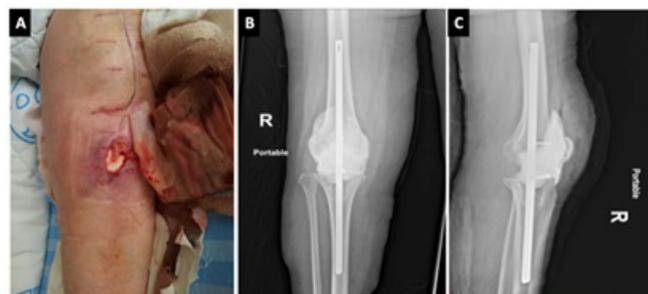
A 74-year-old female who presented with a chronic periprosthetic joint 201 infection in her right knee twelve months after her primary knee arthroplasty. She 202 then underwent a first stage revision with a cement spacer that eventually broke 203 through her skin leaving a large anterior soft tissue defect (A). A decision was made 204 to treat her with a repeat two-stage revision re-implantation, using the static cement-205 nail construct. Immediate anteroposterior (B) and lateral (C) postoperative 206 radiographs at the first-stage operation show the antibiotic-impregnated cement nail 207 construct in situ. Following her first stage revision, the patient was able to ambulate 208 using a walker.
